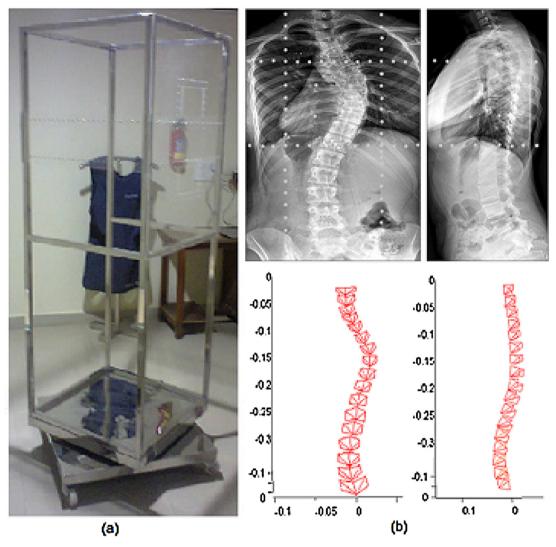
(a) Calibration bench (b) Two views of X-rays and corresponding 3D spine model of subject-1.
